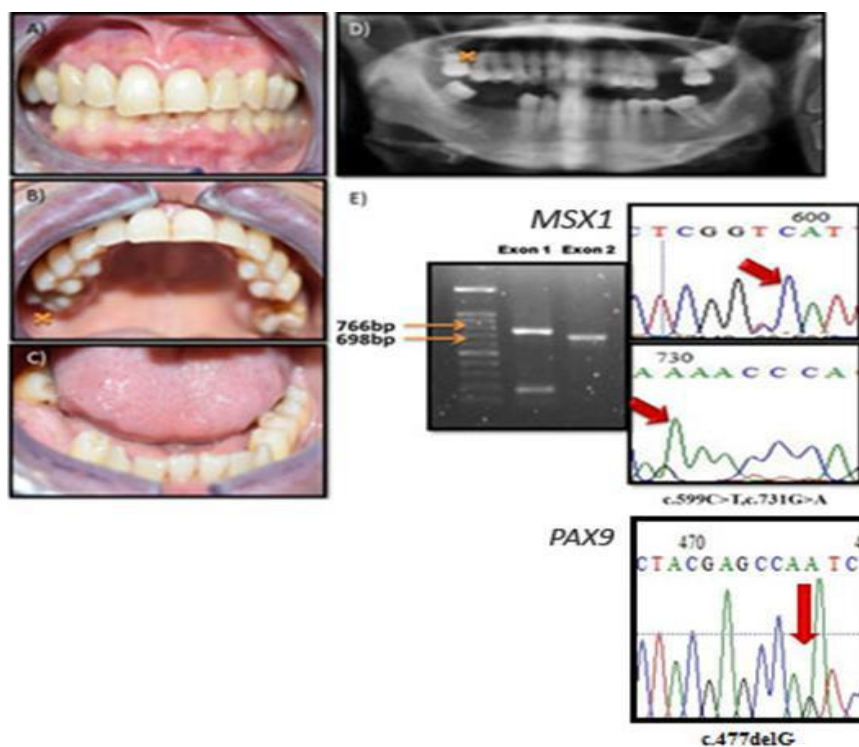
shows sample 1B (mother) of the family clinical findings (A, B, C) showing missing radiographic findings (D) of the respective missing tooth are indicated using 'X'; and genetic findings (E) of electrophoresis and chromatogram show point mutations on exon 2 of MSX1 c.599C>T and c.731G>A and on exon 3 of PAX9 c.477delG.
